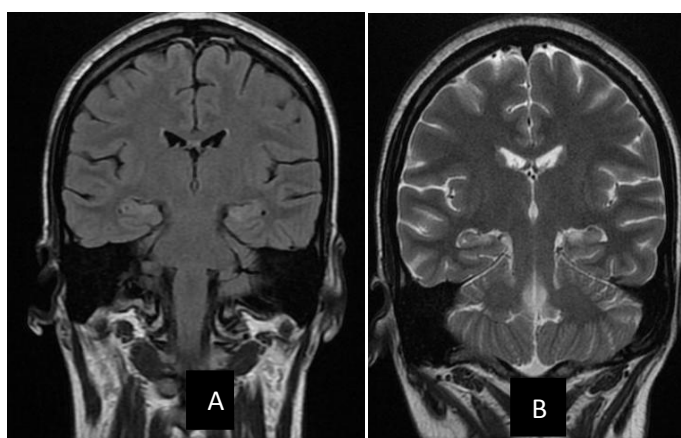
(A & B): COR T2W and T2 Flair image shows bilateral symmetrical altered areas of signal intensities in temporal lobe appearing hyperintense on T2 and FLAIR possibly suggestive of Mesial temporal sclerosis.
